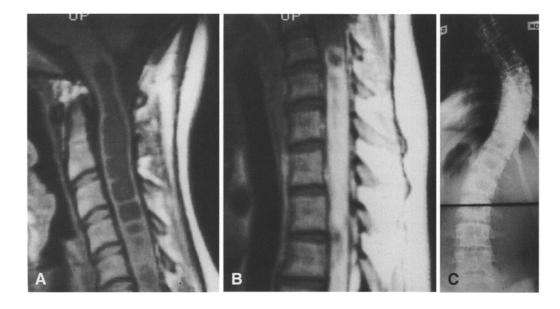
Case 9. A, B Sagittal MRI or 25-year-old woman with right thoracic scoliosis and a cystic spinal cord tumour at C1–T12. C Plain AP radiograph of her scoliosis before spinal fusion at the age of 16 years
